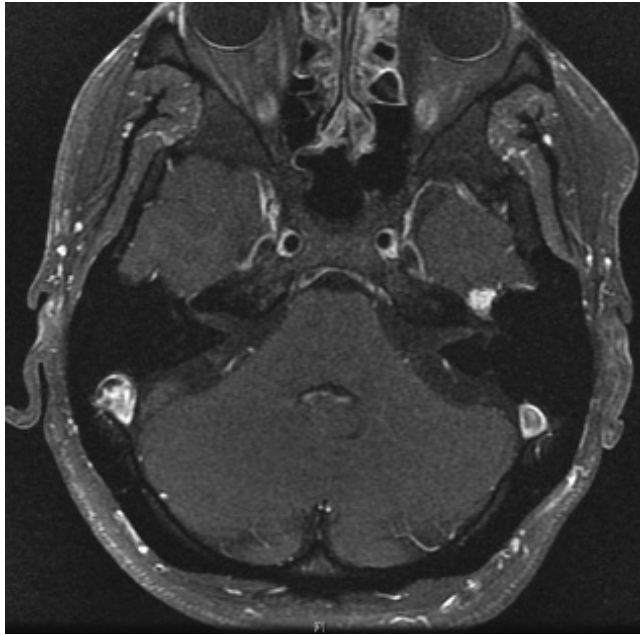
A T1 weighted MRI showing enhancing facial schwannoma of the geniculate ganglion from same patient as Figure 113.4.
